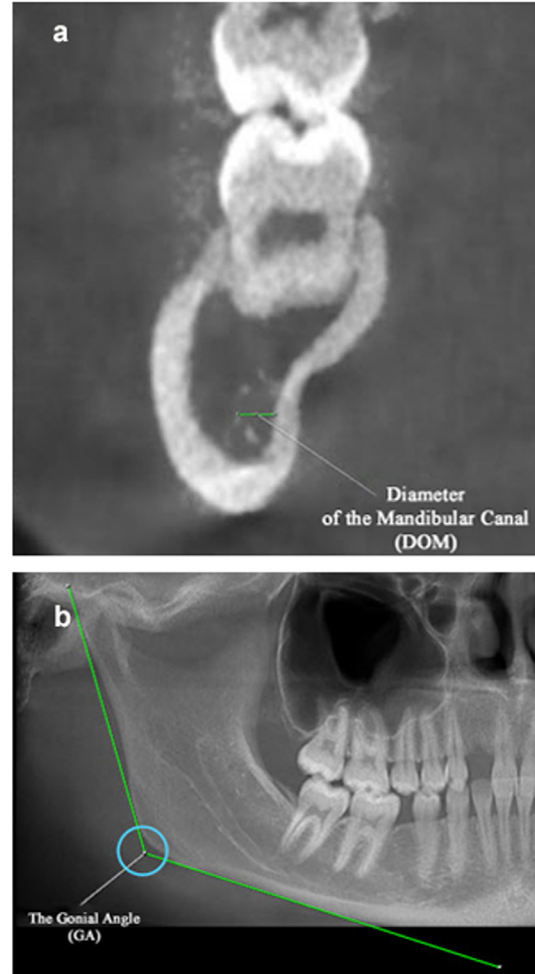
CBCT images of the mandible showing the way to measure both the diameter of the mandibular canal DOM (a) and the gonial angle GA (b).
